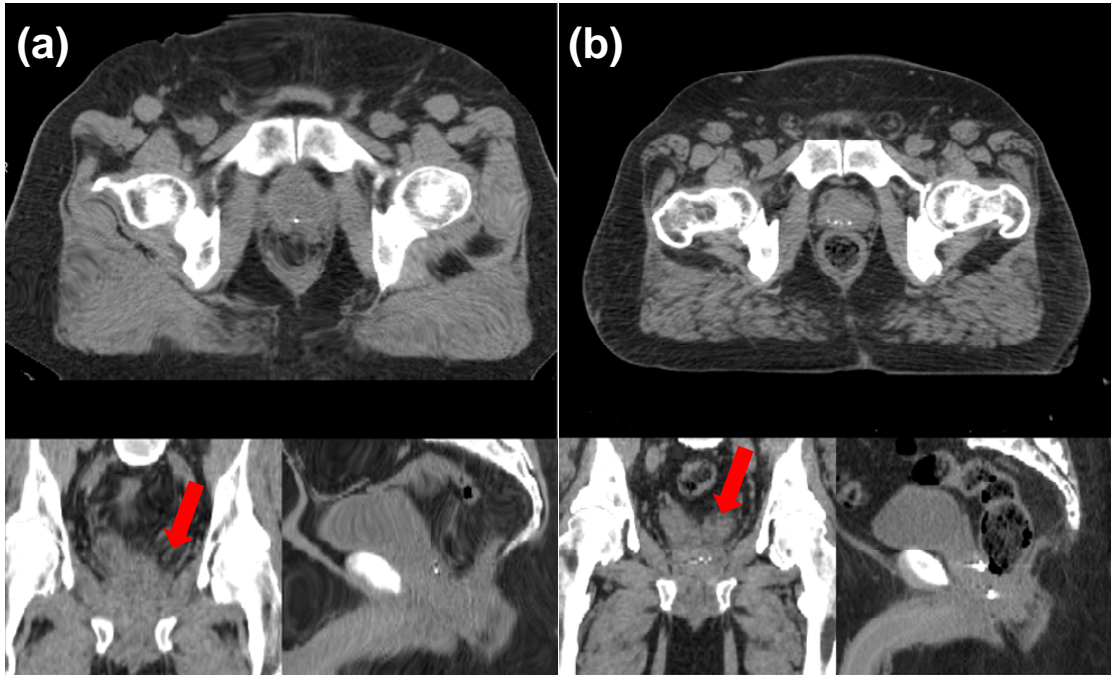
Intensity-based deformable image registration comparison. (a) The deformed CT of the atlas case through the deformation field; (b) the CT of the query case. Variations are observed between images especially at edges (red arrow). Potential error in the edge deformation may degrade the deformable image registration accuracy.
